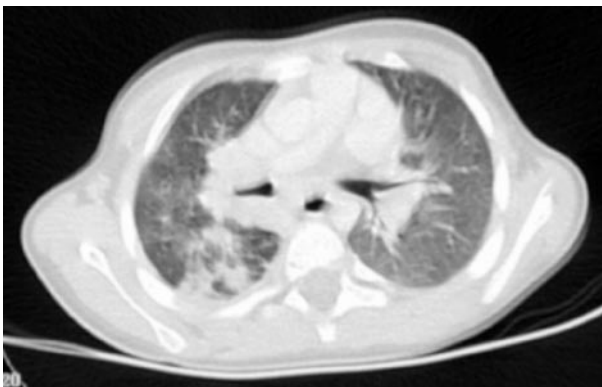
Computed tomography scan of the thorax demonstrating cavitating right lower lobe pneumonia.
